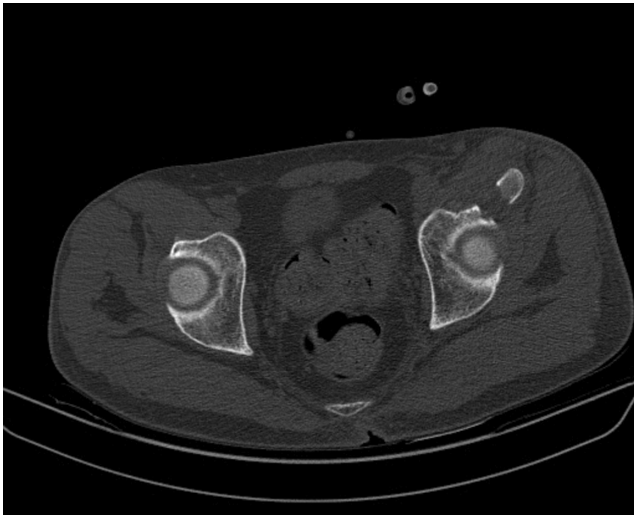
Preoperative axial computed tomography scan demonstrates anterior wall involvement.
